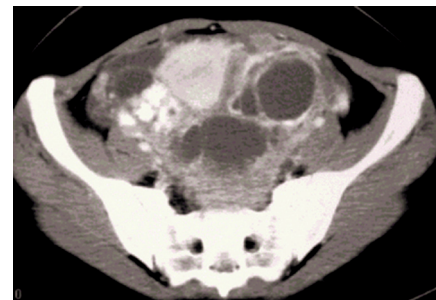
Magnetic resonance image (MRI) of a large, partly cystic ovarian carcinoma
